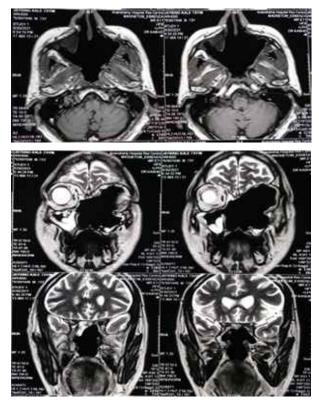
Post operative MRI scan of the same patient with radical FESS & orbital exenteration
